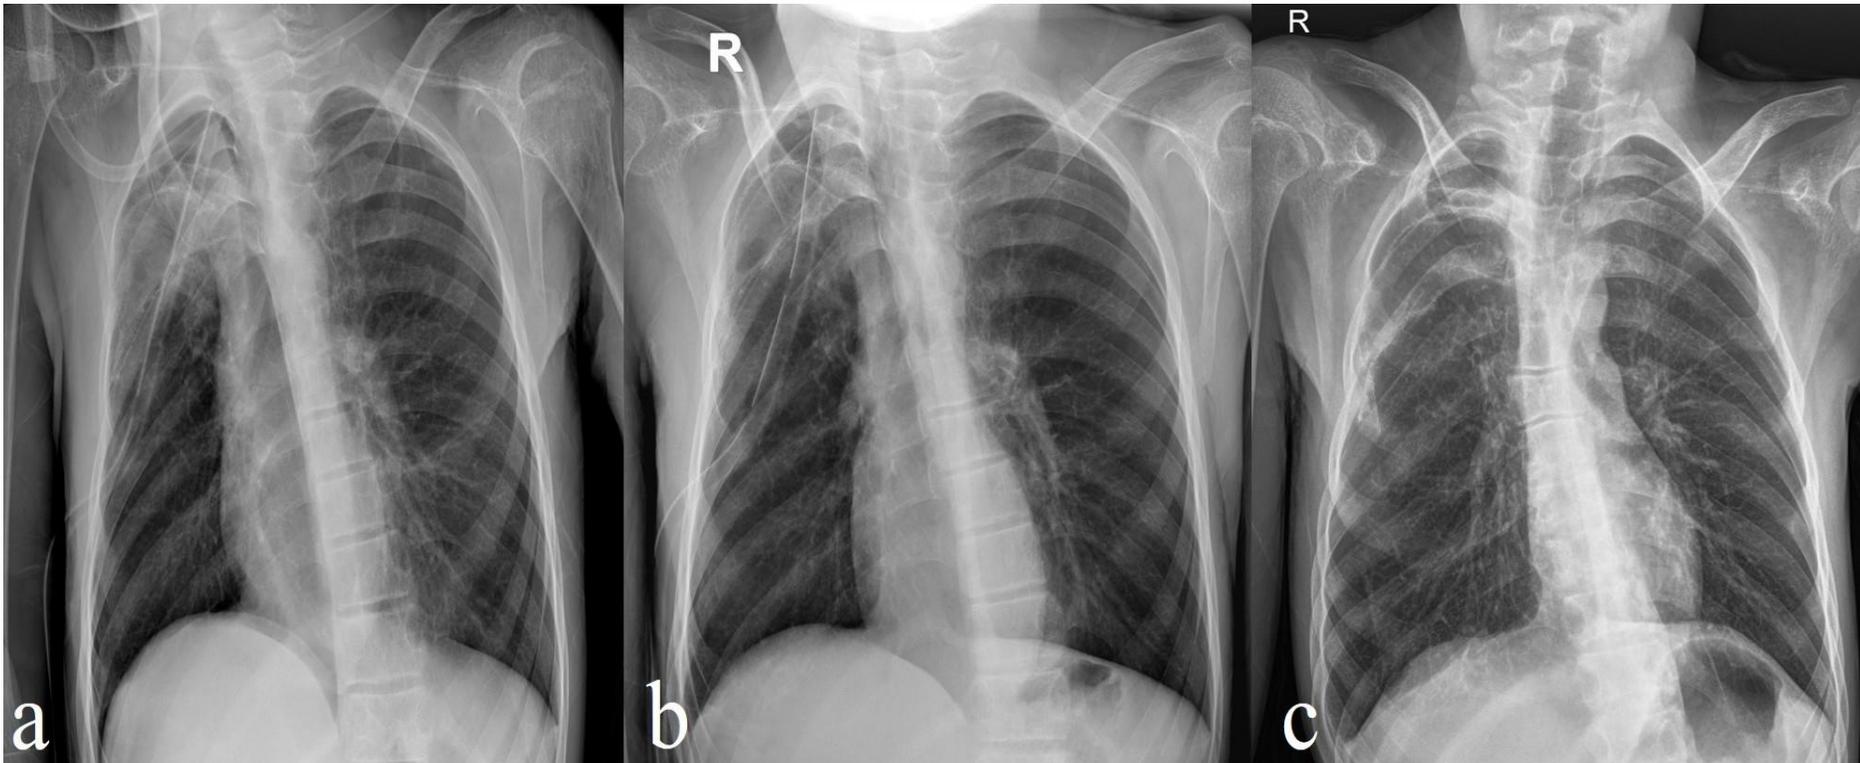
Postoperative chest X-rays:
